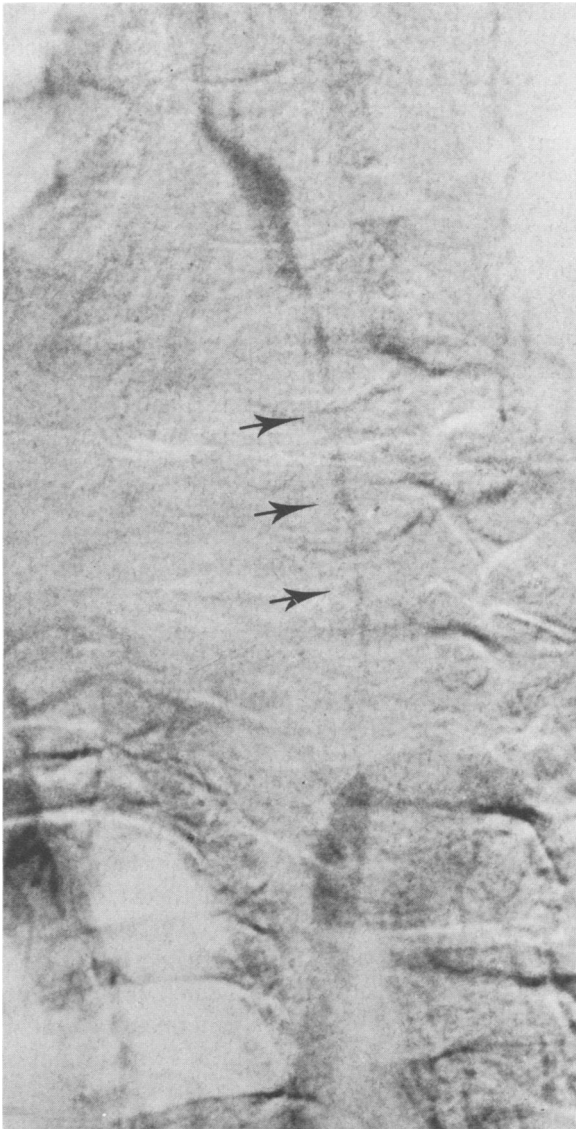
Radiograph showing a long smooth stenosis (arrow) of the left common carotid artery.
